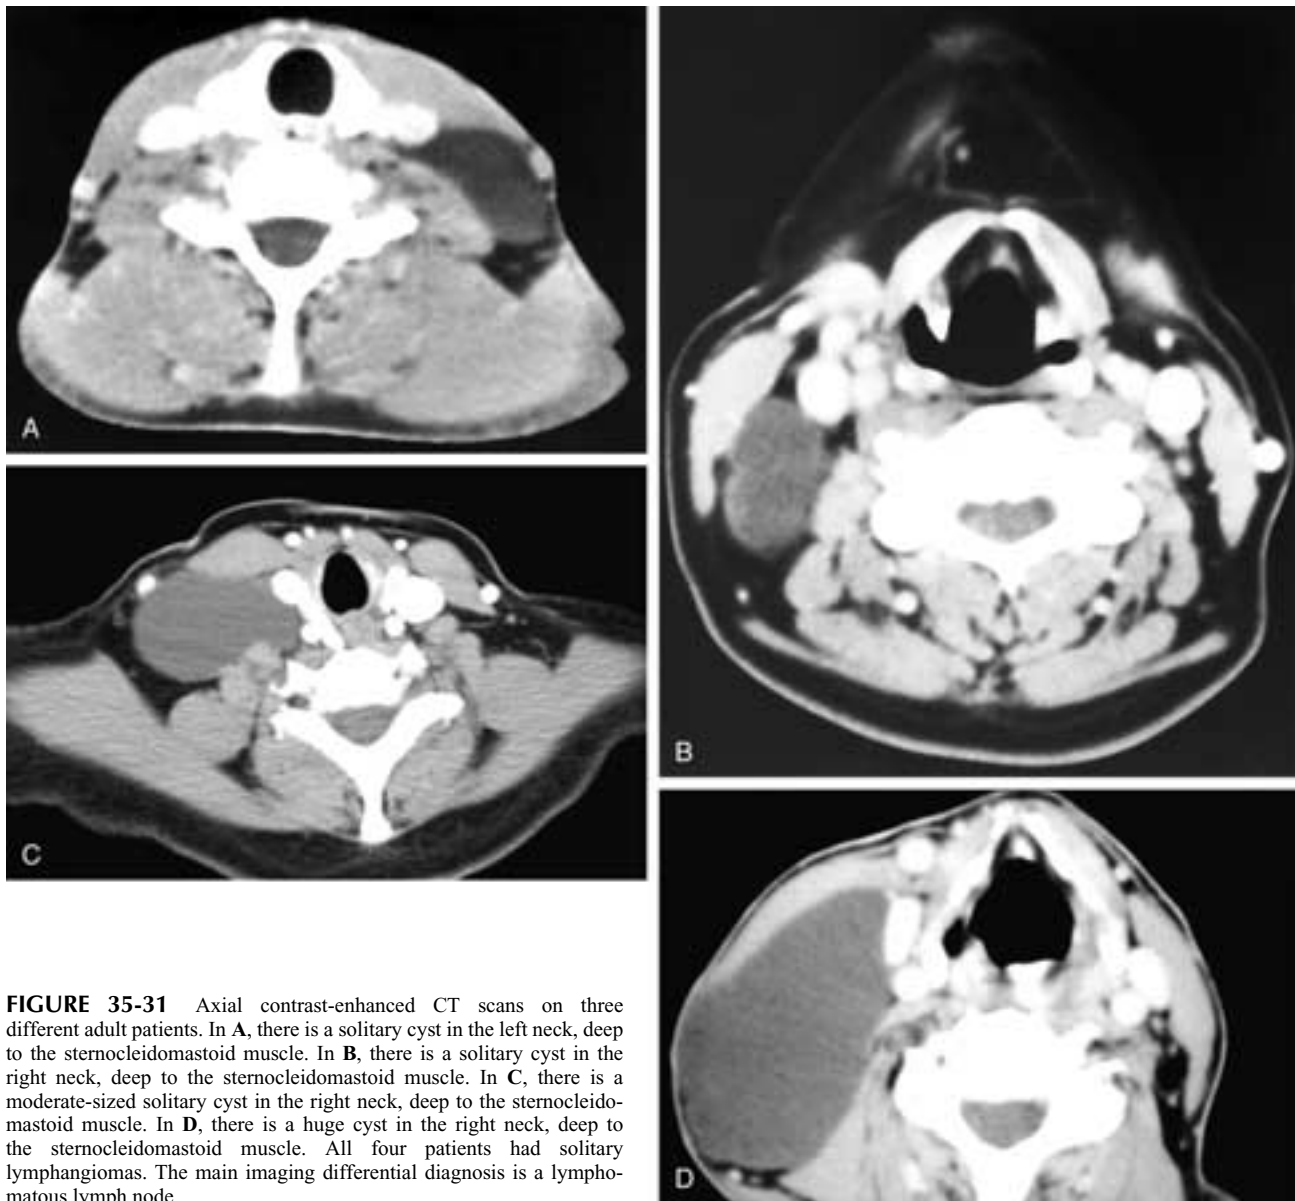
Axial contrast-enhanced CT scans on three different adult patients. In A, there is a solitary cyst in the left neck, deep to the sternocleidomastoid muscle. In B, there is a solitary cyst in the right neck, deep to the sternocleidomastoid muscle. In C, there is a moderate-sized solitary cyst in the right neck, deep to the sternocleidomastoid muscle. In D, there is a huge cyst in the right neck, deep to the sternocleidomastoid muscle. All four patients had solitary lymphangiomas. The main imaging differential diagnosis is a lymphomatous lymph node.
